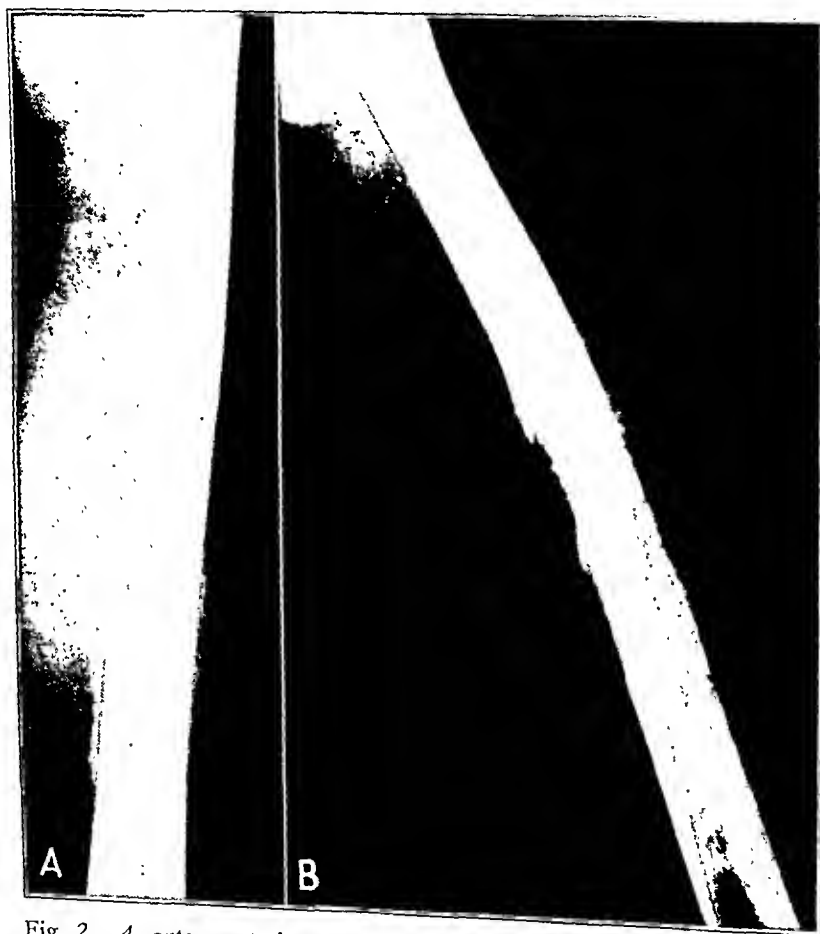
A*, anteroposterior, and *B*, lateral, roentgenogram of the left femur, showing an increasing amount of destruction of the shaft, with considerable formation of new bone.
